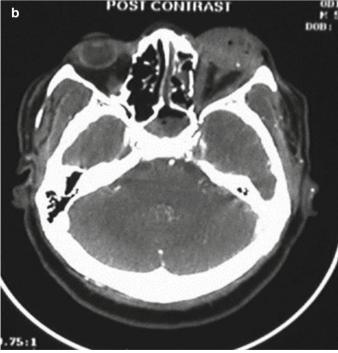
Acute proptosis. (a) Patient at presentation. (b) CT scan. The globe needs immediate protection and possibly a lateral canthotomy (although it also looks internally disrupted)
